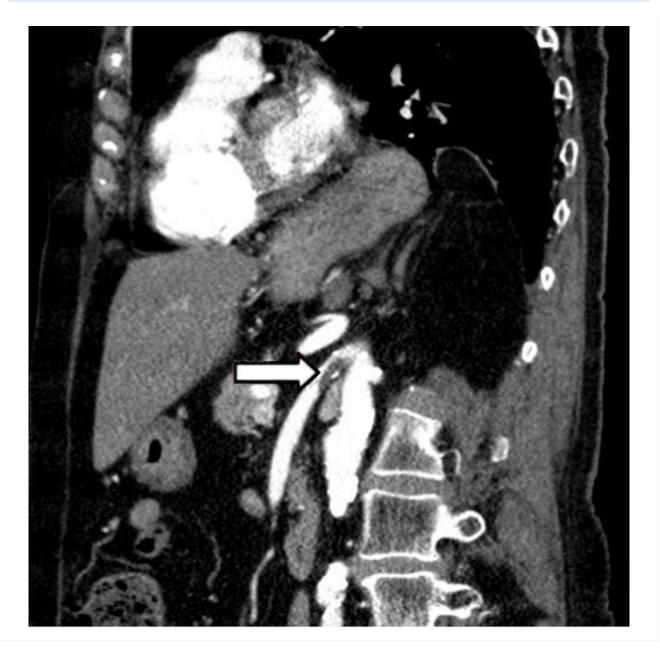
Ischaemic bowel disease: CT angiogram: acute superior mesenteric artery thrombus From the collection of Dr Jennifer Holder-Murray and Dr Alessandro Fichera
